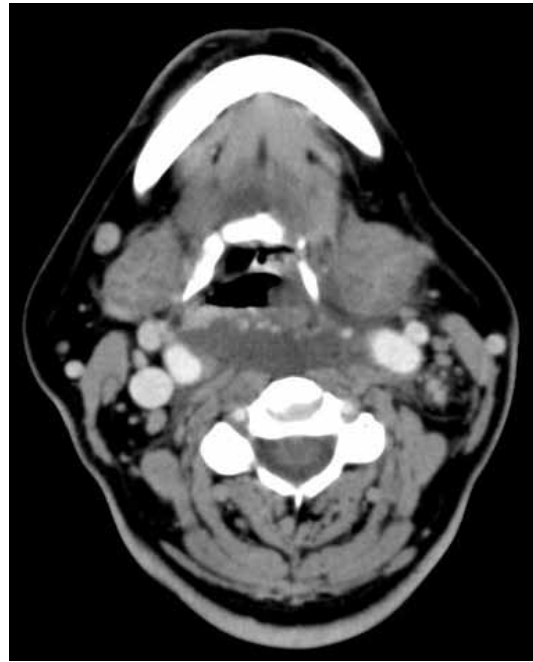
CT image of the neck shows the retropharyngeal space with fluid, communicating with the left visceral space around the thyroid.
